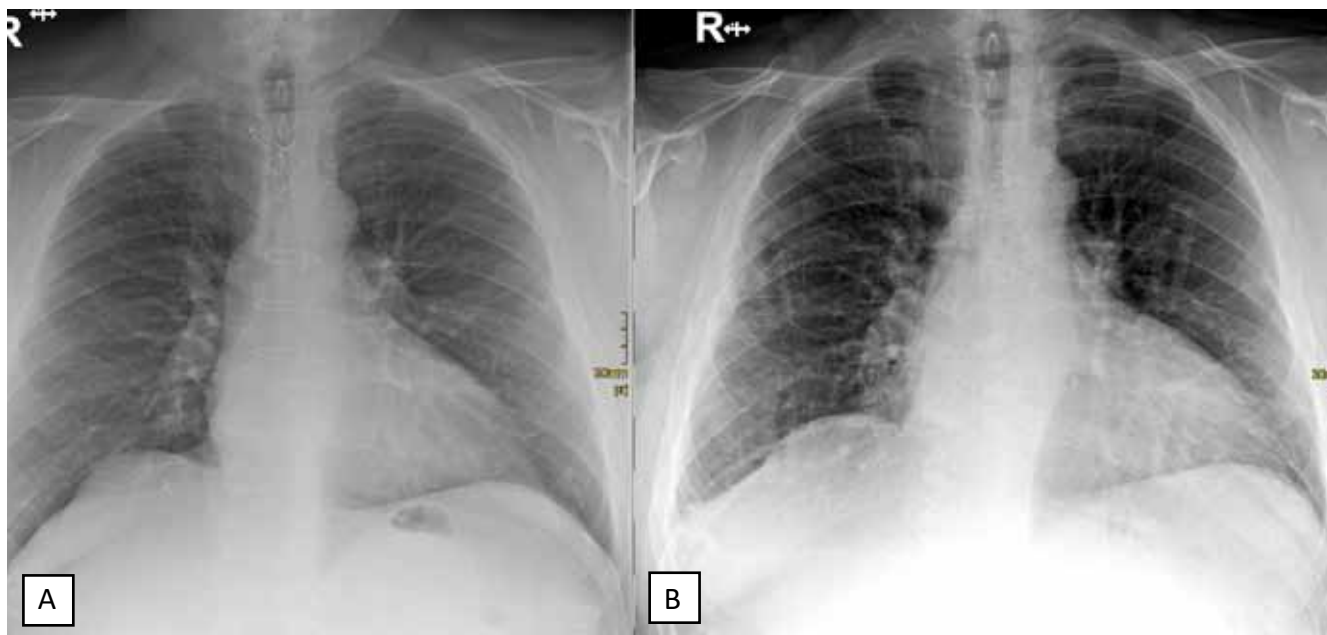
Preoperative radiograph with broken wires and dehiscence. Fig B. Postoperative radiograph with two SuperCables and three wires.
